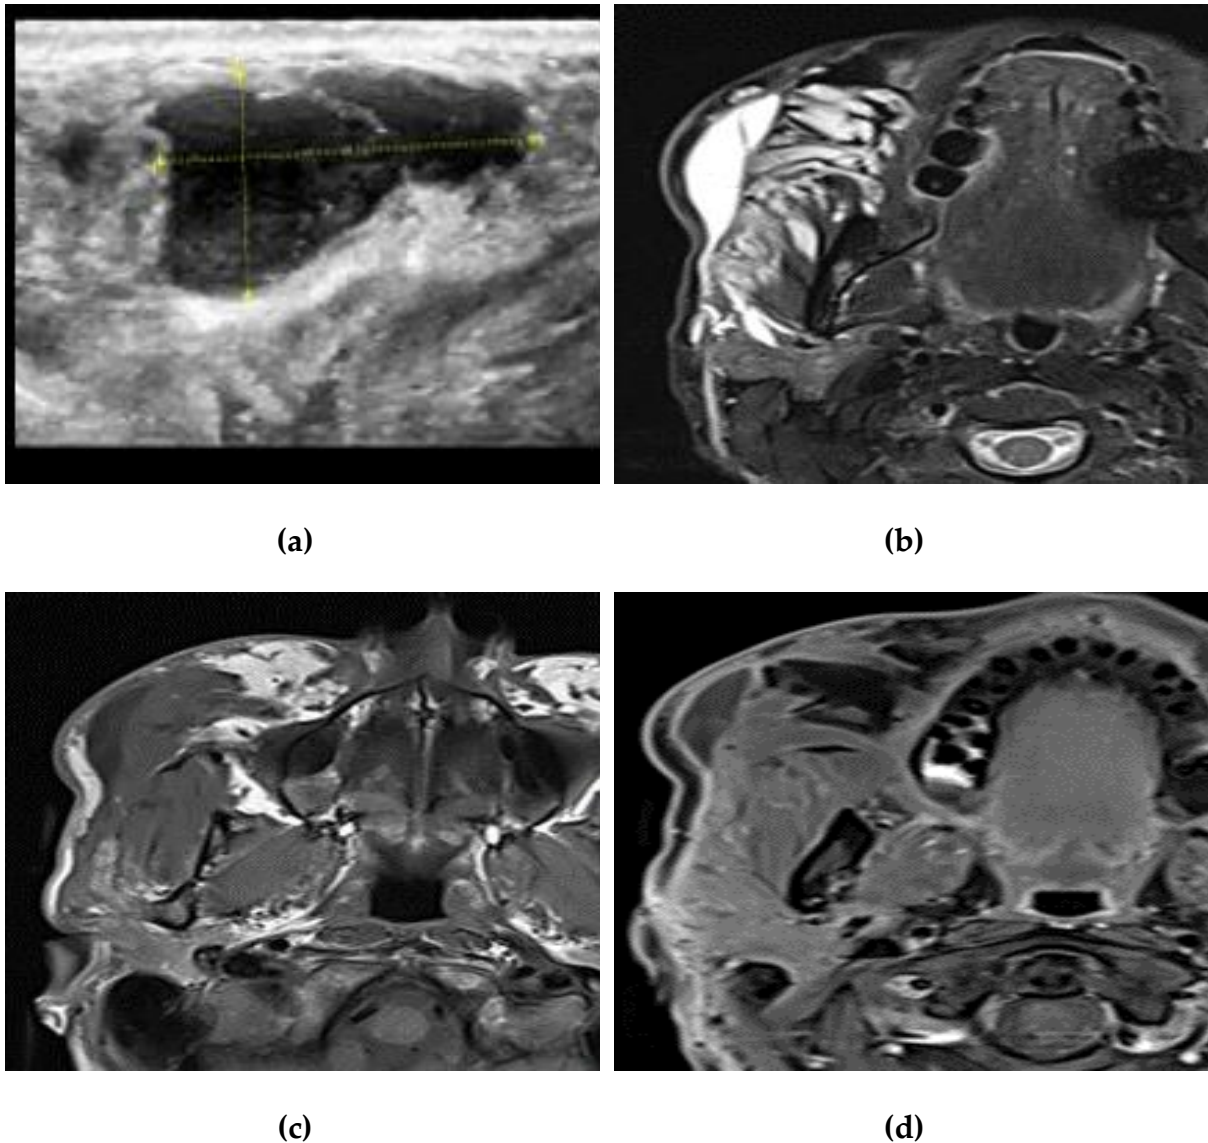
This lady complained of throbbing pain with moderate elevation of temperature, localized redness and irregular skin texture, images show fibrotic changes with partial loculated inflammatory changes and abscess formation (a) US reveals subcutaneous abscess formation with internal echoes and posterior acoustic enhancement , (b) MRI-axial cuts STIR sequence confirming the cystic appearance of the pseudo-loculations and the appreciable wall for the loculated collection, also seen the thick fibrotic plates expressing intermediate to hypointense signals. (c) MRI- axial cuts T1W and T1FAT SAT sequences, reveals intermediate to hypointense linear bands with pseudo-loculations that expresses hypointense T1 signal and a larger loculus that shows complete wall, (d) MRI- axial cuts T1 FATSAT post contrast images; revealed a superficial rim enhancing abscess formation and subtle enhancing fibrotic bands with no other abscess formation.
